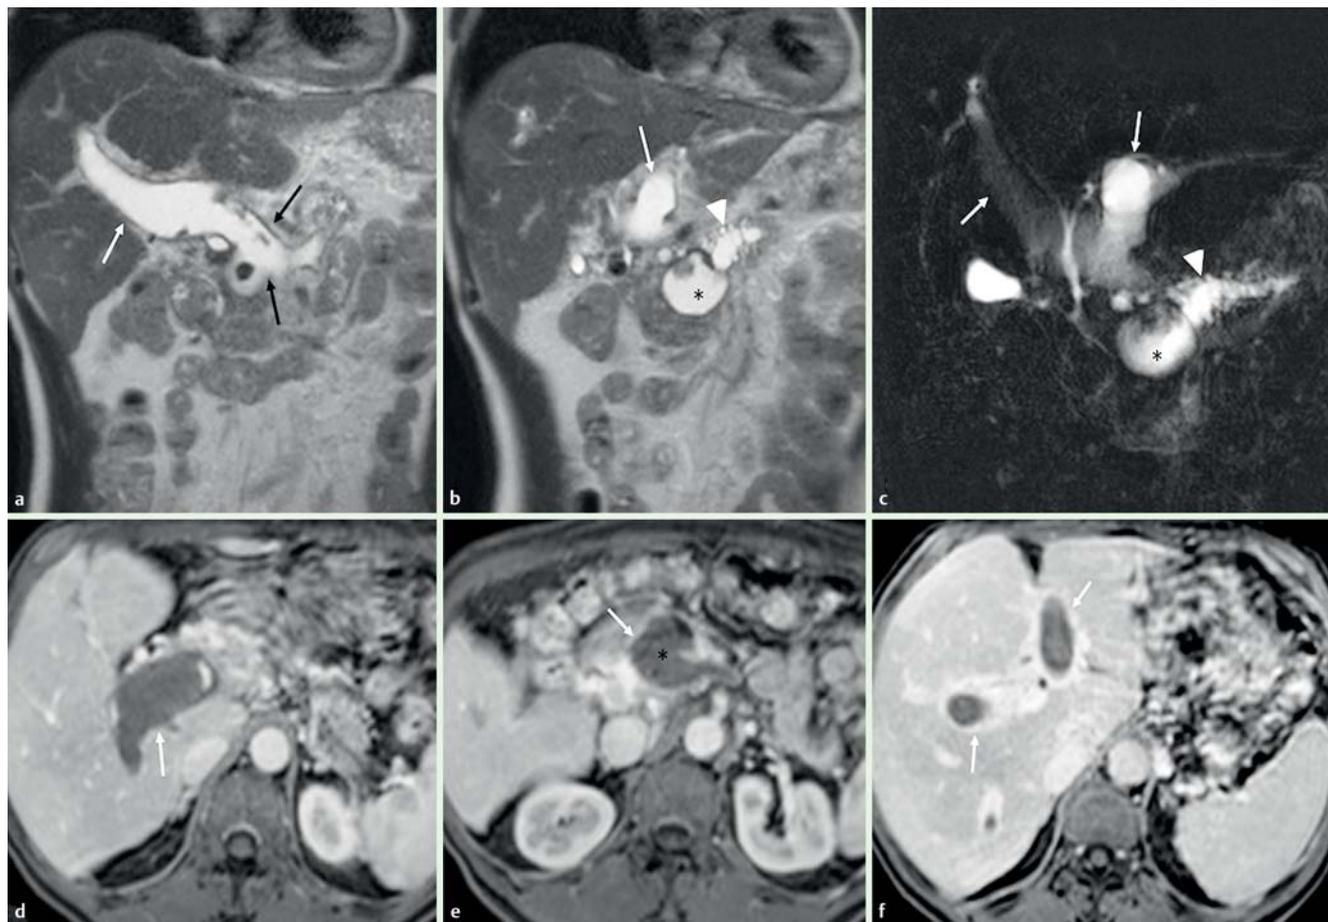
A 69-year-old man underwent magnetic resonance imaging (MRI) 5 months after the onset of abdominal pain and weight loss. The MRI images showed portal vein thrombosis associated with increased caliber and parietal post-contrast enhancement: a, b coronal T2-weighted; c magnetic resonance cholangiography (MRC); d, e portal phase, post-gadolinium, fat-suppressed, T1-weighted; f late phase, post-gadolinium, fat-suppressed, T1-weighted. The pancreaticoportal communication, probably related to the pancreatic head pseudocyst is seen in part a (black arrows). The portal vein thrombus (white arrows, a–c) appears hyperintense on the T2-weighted and MRC images, most likely because of liquefaction caused by pancreatic juice. Lack of enhancement of the portal vein caused by thrombosis is shown on post-contrast T1-weighted images (white arrows, d–f), and parietal portal vein enhancement, probably related to inflammation, can be better seen on the late post-contrast phase image (f). The pancreatic head pseudocyst (*) is seen in parts b, c, and e. The dilated main pancreatic duct (arrowhead) is seen better in parts b and c. The normal biliary tree and gallbladder can be seen in part c, partially superimposed by portal vein thrombosis.
